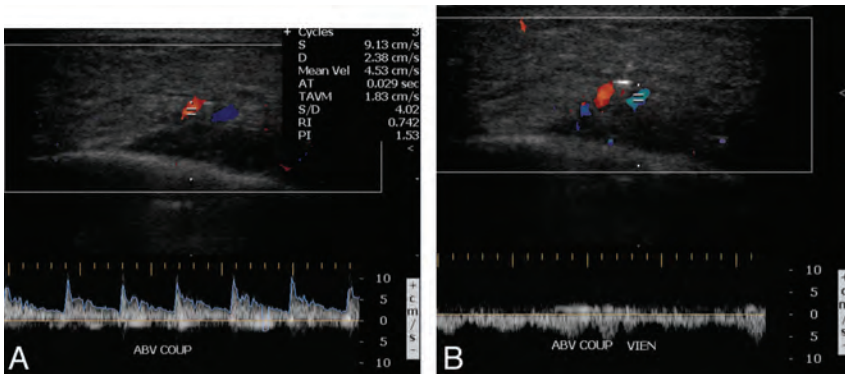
Gracilis free flap. Color Doppler sonographic images of the vascular pedicle show normal arterial (A) and venous (B) waveforms.
